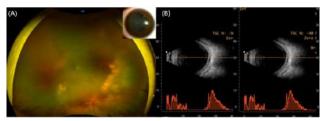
Fundus picture of the left eye on presentation showing media haze along with retinitis patches and retinal detachment in the ITQ; Inset showing festooned pupil indicating inflammation. Figure 1B. Ultrasound B scan revealing reflective membranous echoes in ITQ suggestive of retinal detachment.
